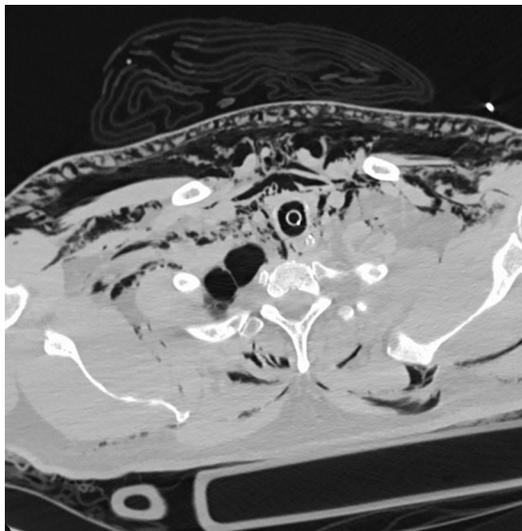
CT chest of a trauma victim with evident subcutaneous emphysema and mediastinal air tracking superiorly into the anterior chest wall and neck.
